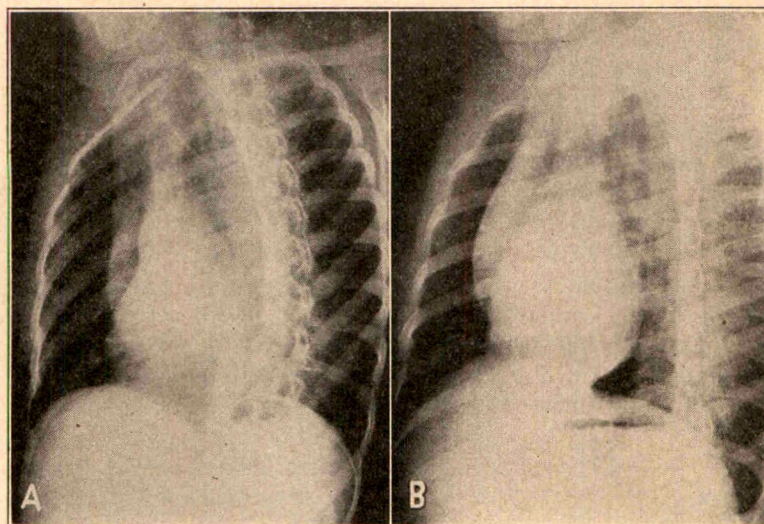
Roentgenograms taken with the subject in the left anterior oblique position, *A*, showing the first angle of clearance, with the posterior border of the cardiac silhouette clearing the projection of the transverse processes and *B*, showing the second angle of clearance, with the posterior border of the cardiac silhouette clearing the anterior border of the vertebral bodies.
